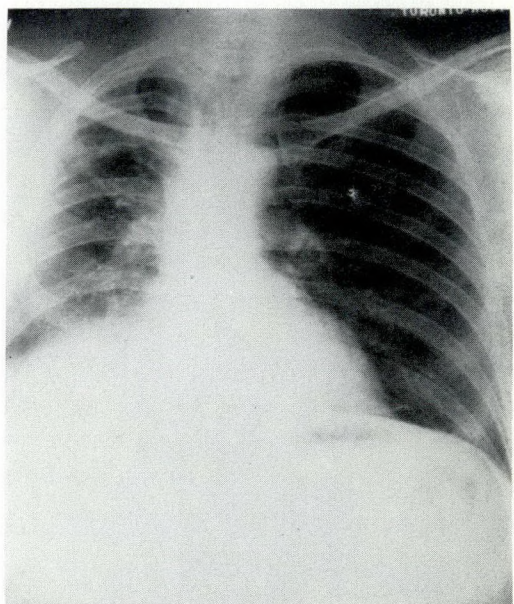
J.W. Chest radiograph July 21, 1967. The pleural space has been obliterated by a right parietal and visceral decortication.
